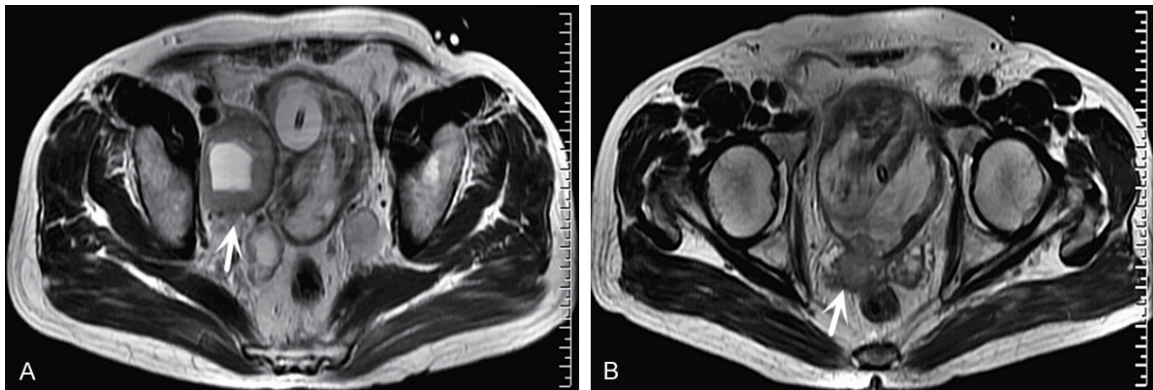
MRI of the prostate gland revealed a focal nodule located in the pelvic cavity compressing and displacing the right bladder wall (A) and the prostate invaded the bladder and seminal vesicle (B).
